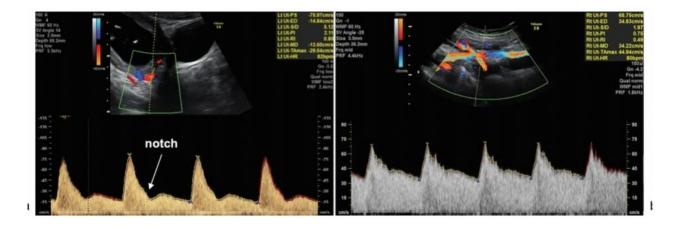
Doppler waveforms of the uterine arteries showing a high resistance pattern with notching between the systole and the diastole (a) characteristic of the 1st trimester, and a low resistance pattern (b) characteristic of the 2nd trimester.
